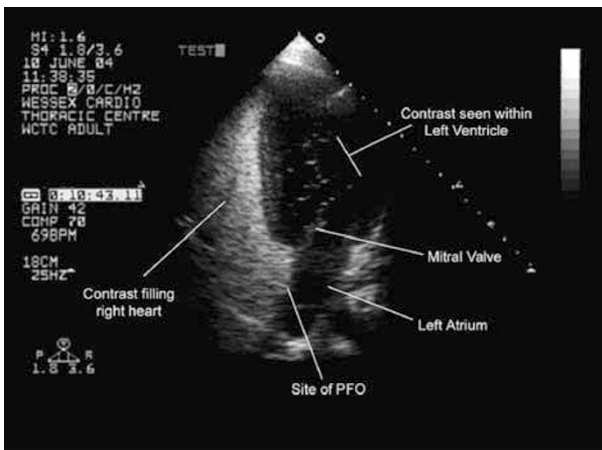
Four chamber transthoracic echocardiogram showing passage of contrast from right to left heart across the patent foramen ovale.
